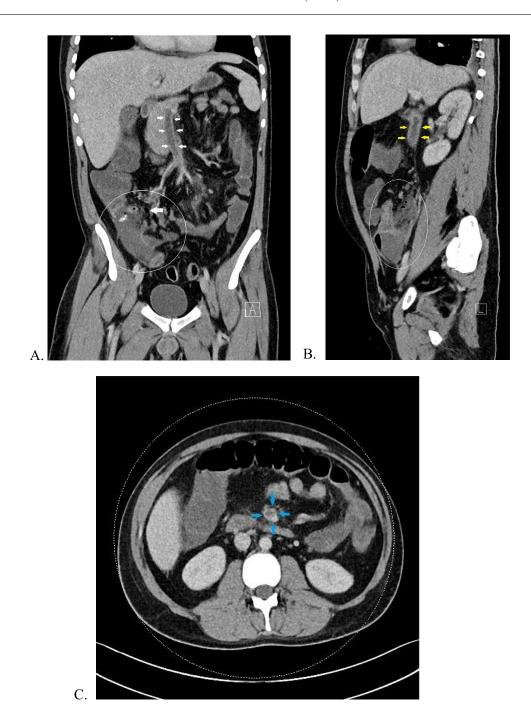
(A and B) Coronal and sagittal contrast-enhanced CT images demonstrating the filling defect (thrombosis) inside the enlarged SMV (small white arrows). In image (B), the filling defect extends into the portal vein (yellow arrows). In the right lower segment of the abdomen (white circle) on images (A and B), there is an abscess-formation measuring $5 \times 5 \times 10$ cm (SSxAPxCC), along with periappendiceal free fluid and extraluminal gas indicating perforated appendicitis (thick white arrow). (C) Axial contrast-enhanced CT image showing a visible filling defect in the SMV (blue arrows).
